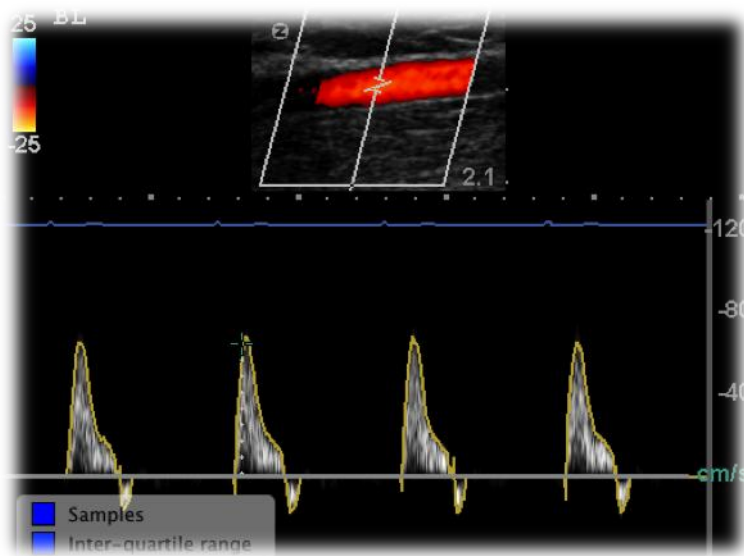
Frozen screen shot of a Doppler image
